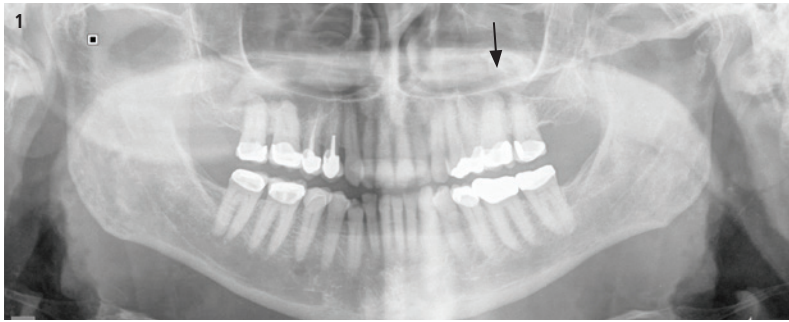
Orthopantomograph of the patient showing the fractured left maxillary sinus and a poorly defined radiopacity within the sinus. – Fig. 2: The submentovertical view showing the fractured left zygomatic complex. – Fig. 3: The lateral radiograph showing the foreign body within the left maxillary sinus.
